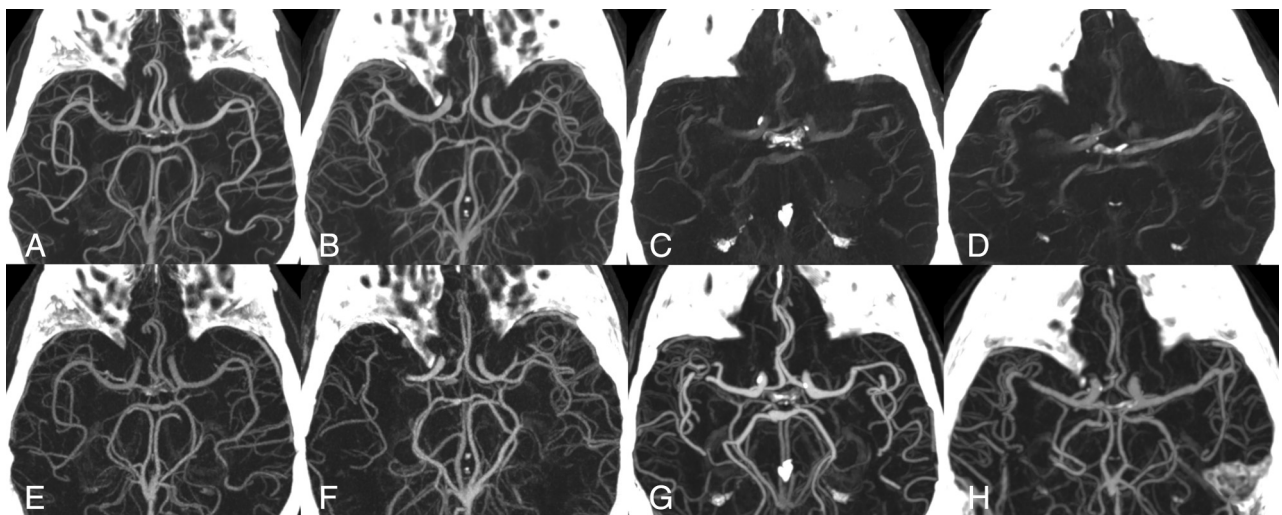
DL-CBCTA 70-keV images (upper row) and CTA (lower row) with MIP 35-mm section thickness. A and B, Acceptable-quality DL-CBCTA scans. C and D, Typical scans in the data set affected by motion artifacts. Lower row (E–H) shows the corresponding CTA. Note that images F, G, and H show a right-sided MCA occlusion, which have been resolved at the time for DL-CBCTA imaging. Only the arterial anatomy in the unaffected hemisphere was evaluated in this study.
